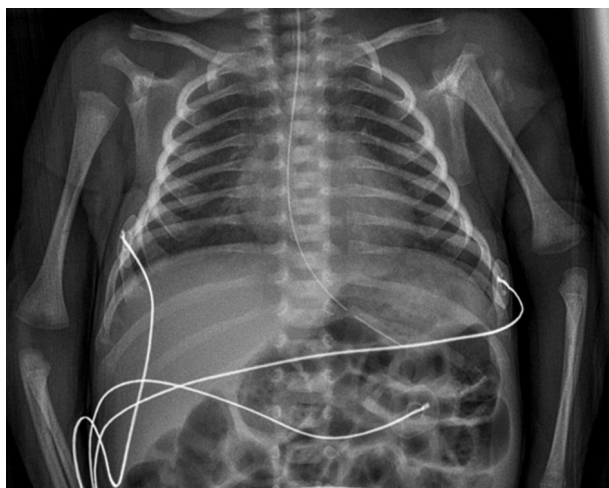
Follow-up of the anteroposterior chest radiography obtained on the 15th day of life, showing visible bone callus formation at the site of the humeral head.
